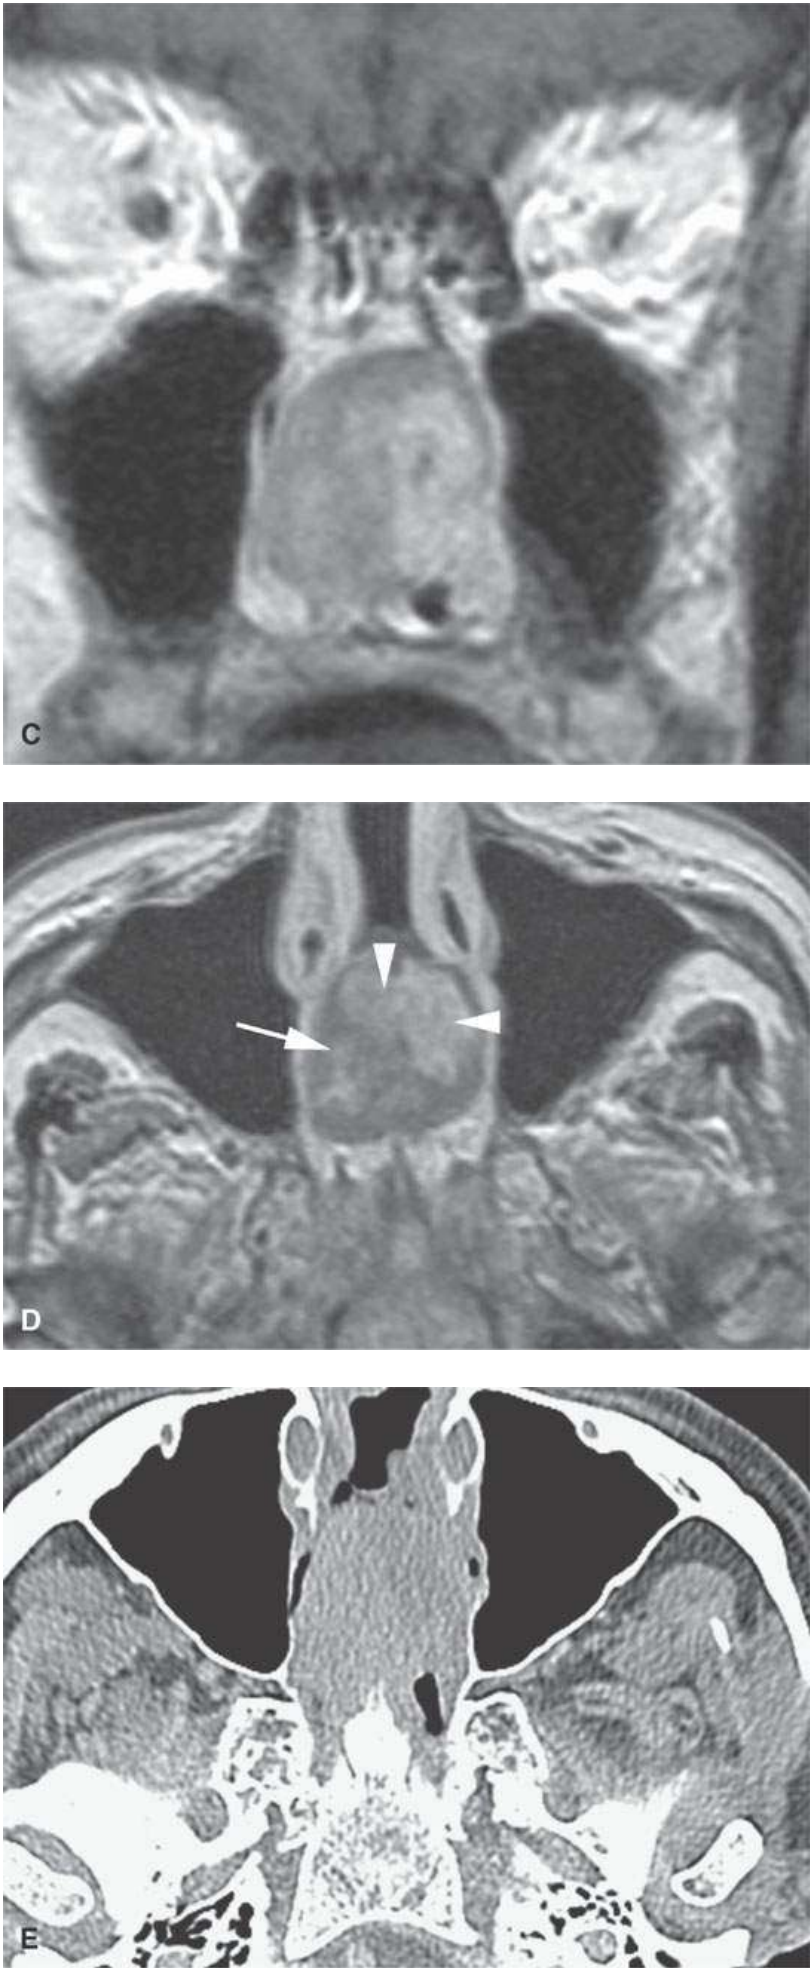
Magnetic resonance imaging and computed tomography of a patient with acinic cell carcinoma of the nasal cavity. A: Non-contrast-enhanced T1-weighted (T1W) image. B: T2-weighted (T2W) image. C, D: Contrast-enhanced T1W coronal and axial images showing zones that enhance (arrowheads in D) and those that do not (arrow in D); the enhancing zones tend to correlate with brighter zones on the T2W images, but this is nonspecific. E: Contrast-enhanced computed tomography.
